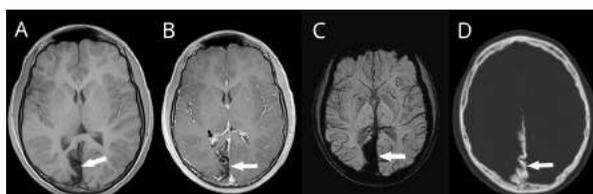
T1W before (A) and after (B) gadolinium administration in the axial plane; White arrows indicate leptomeningeal enhancement in the right parasagittal occipital region; Black arrow in B indicates hyperplastic enhanced ipsilateral choroid plexus; SWI (C) and CT (D) confirming the presence of “tram-like” corticopial calcifications in the same location
